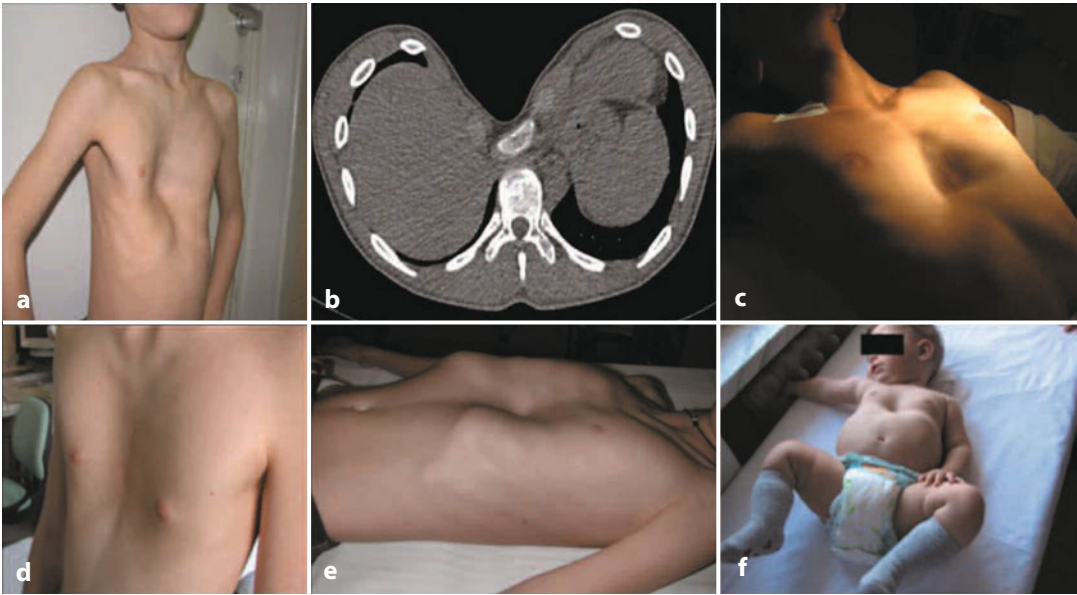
First row: Grand Canyon-shapes PE (a). CT of the thorax showing a Grand Canyon-shaped PE with sternal rotation (b). Punch-shaped PE (c). Saucer-shaped PE (d). PE with flaring chest (e). Congenital punch-shaped PE (f)
